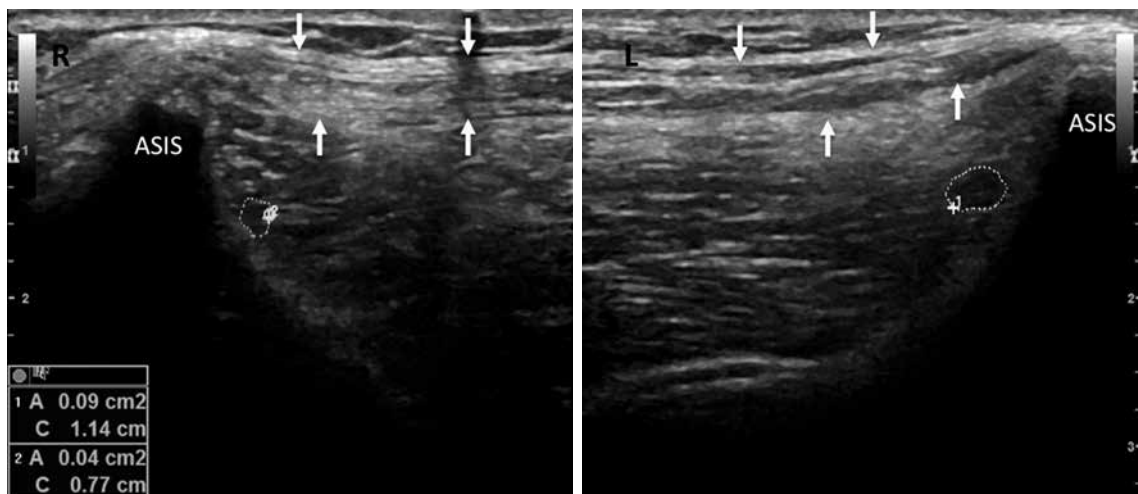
Transverse sonographic image demonstrating the lateral femoral cutaneous nerve (dashed line circles) and the inguinal ligament (arrows).
